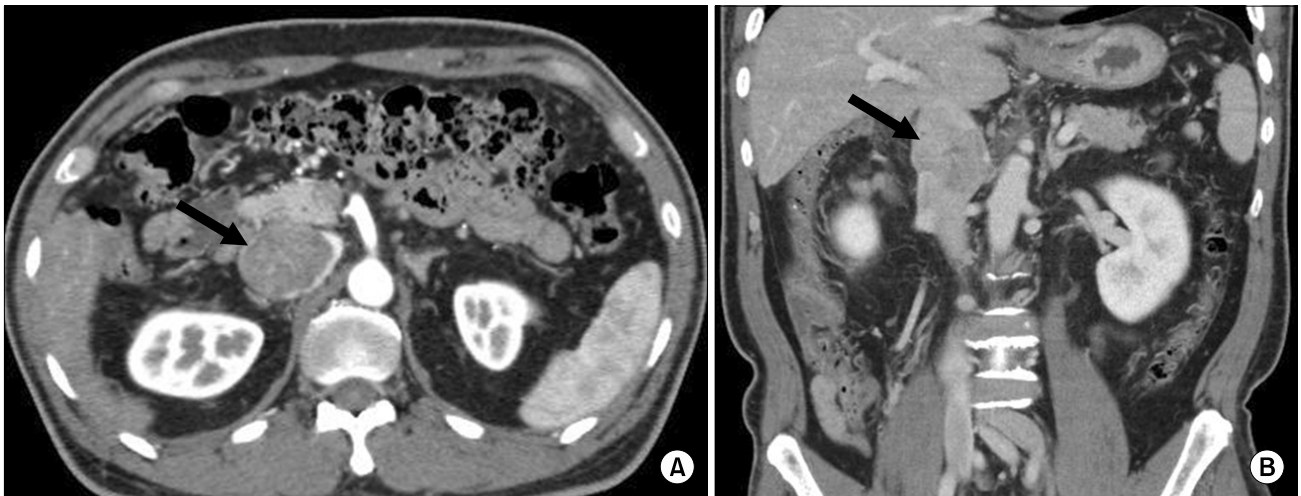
Preoperative computed tomography shows a mass in the inferior vena cava. (A) Axial view. (B) Coronal view.
